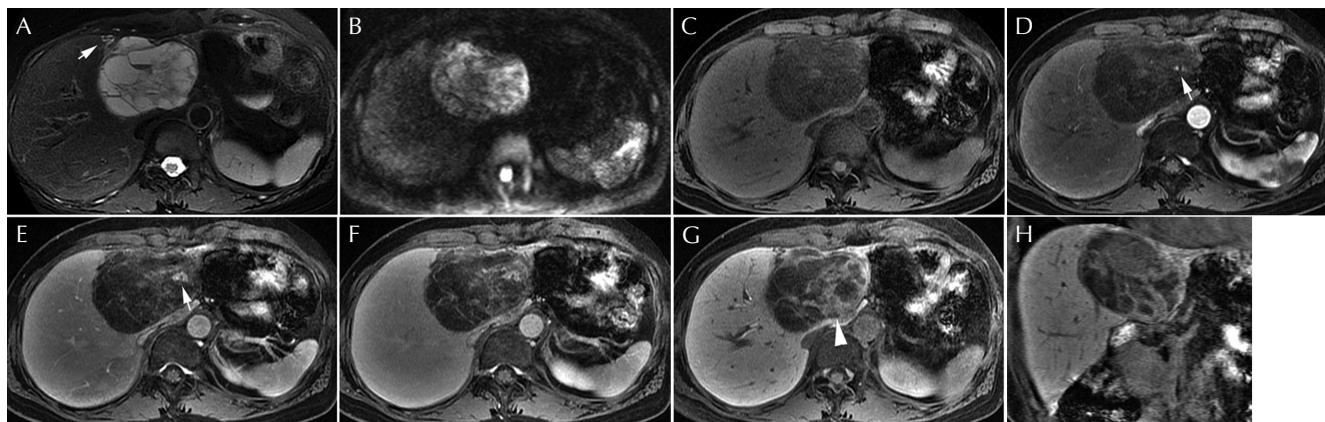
Plain and EOB-enhanced MR images. (A) Fat-saturated T_2 -weighted and (B) diffusion-weighted (b-value = 1000 s/mm^2) images demonstrate a heterogeneous hyperintense multi-cystic mass with a thin capsule. Some loculi of the mass show hyperintensity on (C) pre-contrast fat-saturated T_1 -weighted imaging reflecting hemorrhage, and some of them reveal fluid-fluid levels on (A) fat-saturated T_2 -weighted imaging due to plasma-blood separation. (D–G: D, arterial phase [32 sec]; E, portal phase [70 sec]; F, late phase [180 sec]; G and H hepatocyte phase [15 min]). Gadoteric acid disodium-enhanced MR images show some nodular arterial enhanced areas (arrows) and several gradually enhanced solid-like areas along the septa (arrowhead) during dynamic phases (D–F), and they showed slight hypointensity at the hepatocyte phase (G). The mass was primarily located at segment 4 and protruded toward the hepatic hilum (H). Mild intrahepatic duct dilatation (arrow) is also observed at the periphery of the mass (A). Notably, the cystic part appears as a clearly more hypointense area compared to the solid-like part at the hepatocyte phase (G), although the solid-like and cystic parts are similarly hyperintense on fat-saturated T_2 -weighted (A) and diffusion-weighted images (B).
